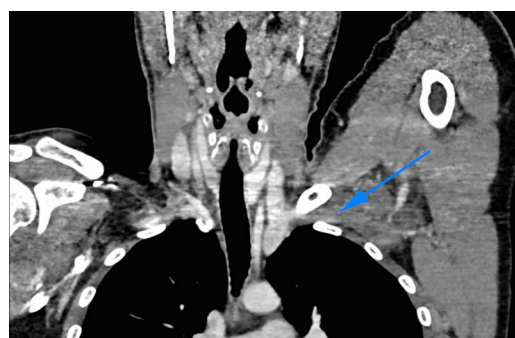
CT venogram coronal slice. Blue arrow: thrombus in the left subclavian vein.
